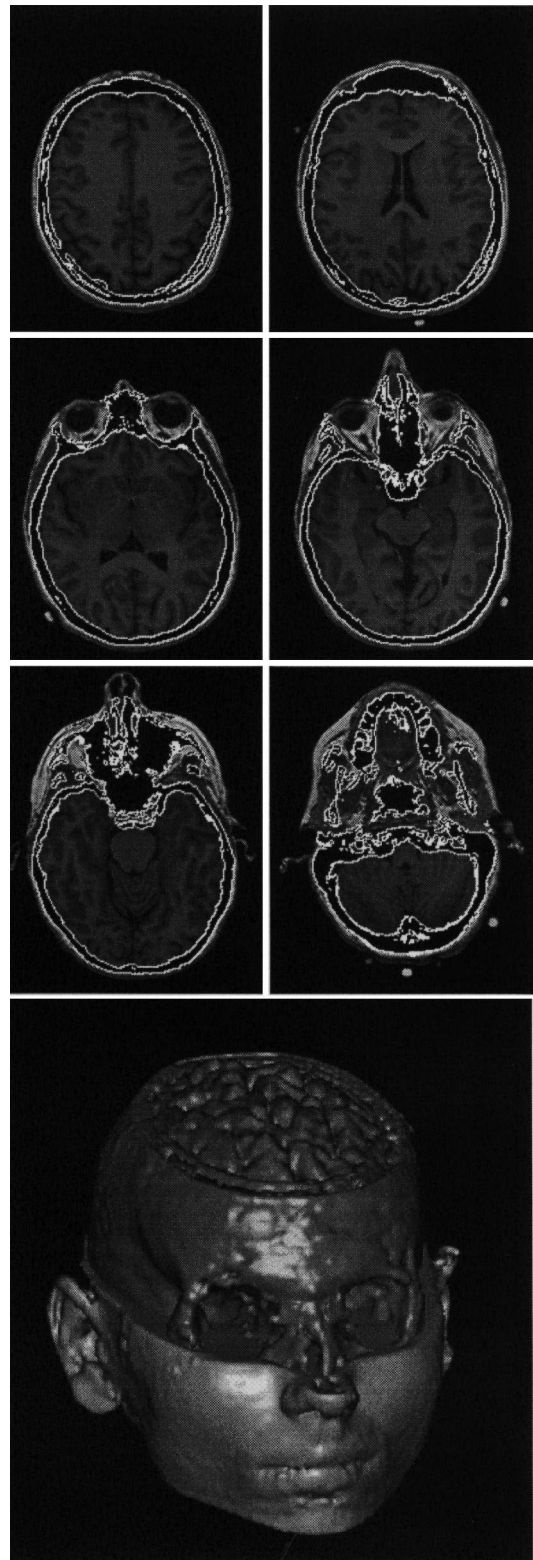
The result of the skull segmentation of the volume  $A$ .  $\delta_1 = 2$ ,  $\Delta t = 0.02$ ,  $\varepsilon = 0.001$ . In the 3D representation, the brain is obtained by morphological segmentation, the skull is segmented using the deformable model and the remainder of the head is obtained from the original MRI volume.
